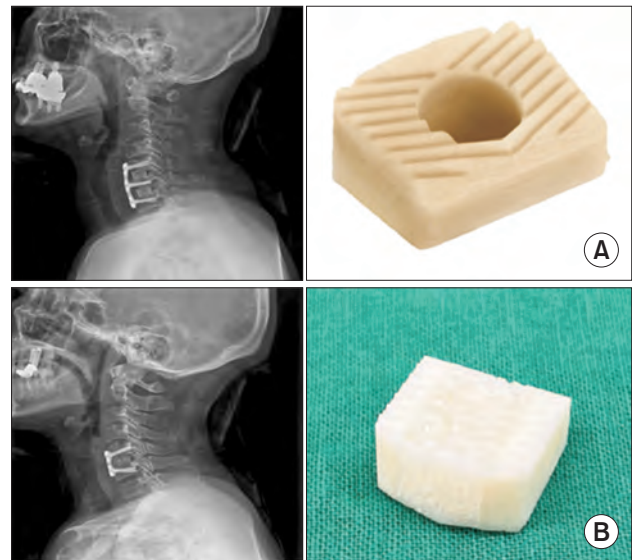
Allograft materials: cortical ring and cortico-cancellous types. (A) Plain cervical lateral radiograph of a patient operated using cortical ring allograft and the structure of the cortical ring allograft. (B) Plain cervical lateral radiograph of a patient operated using cortico-cancellous allograft and the structure of the cortico-cancellous allograft.
